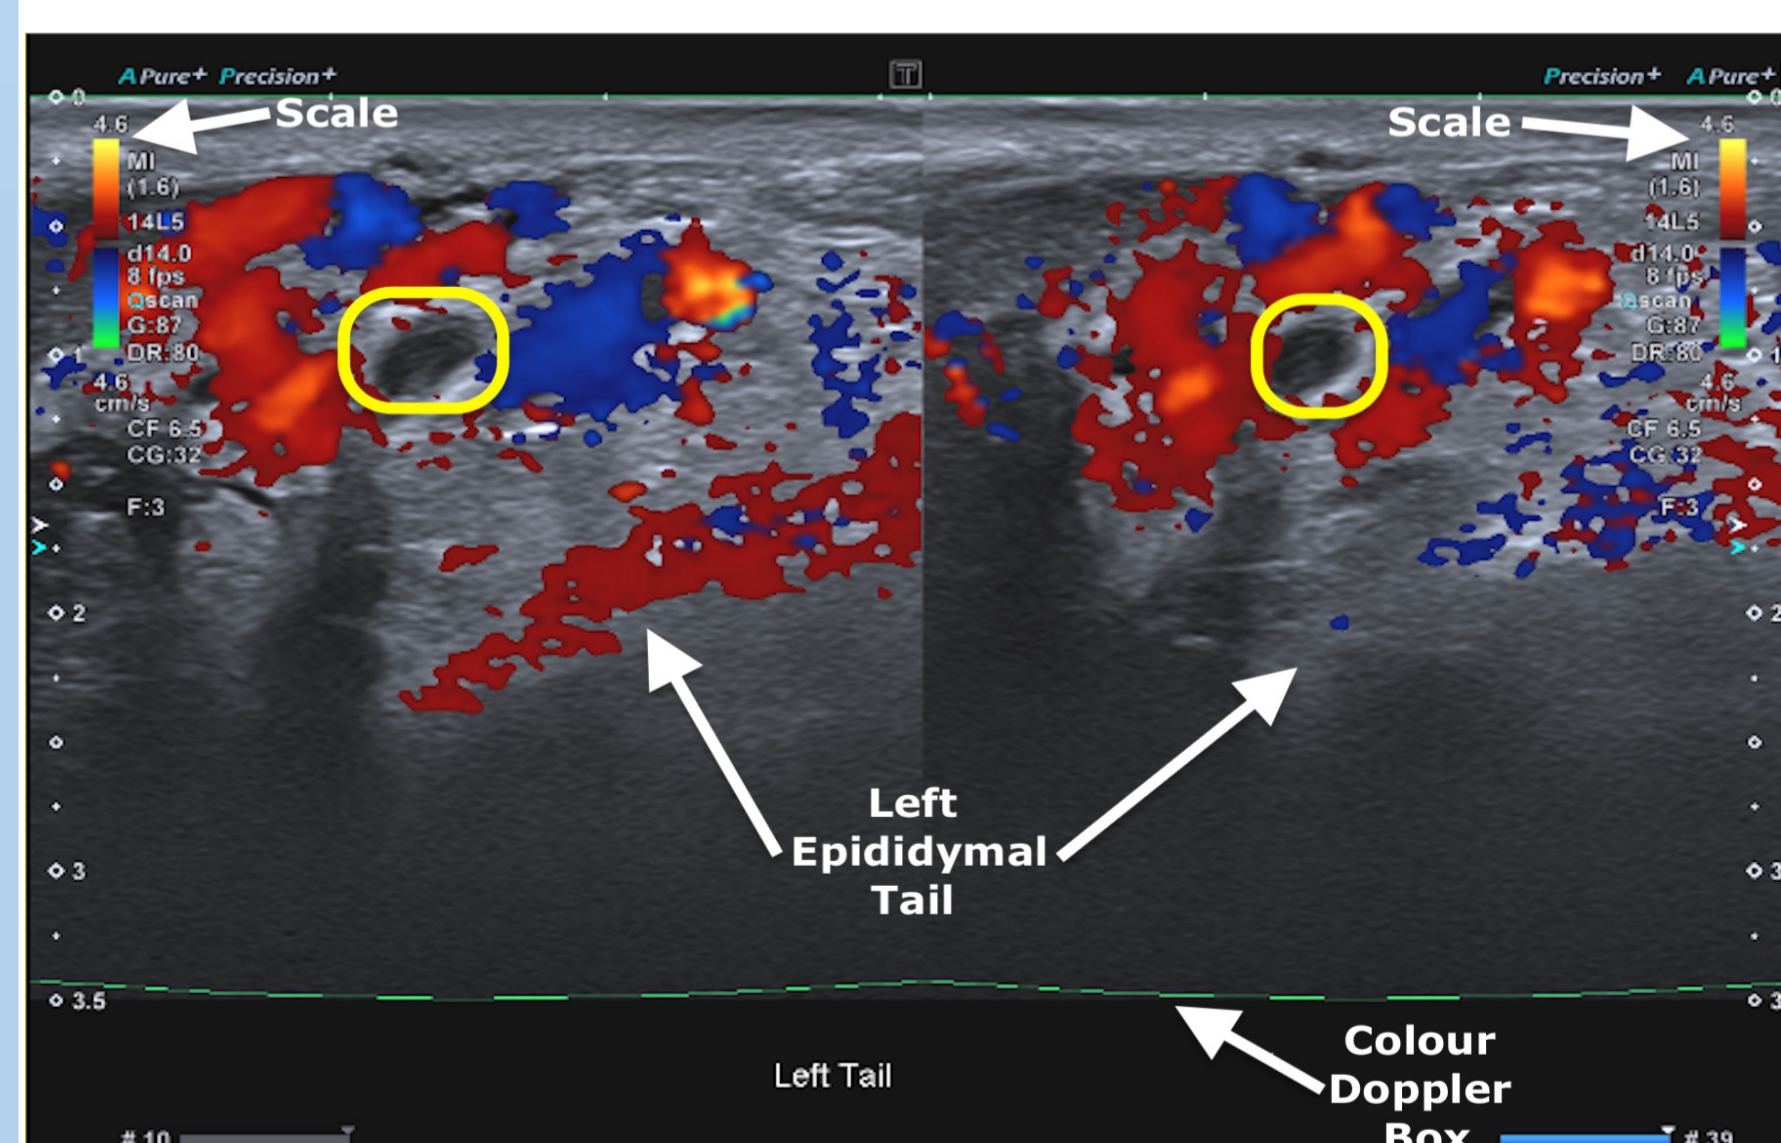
Colour doppler of the left epididymal tail, demonstrating blood flow within the varicocele, combined with a small avascular segment imaged during Valsalva (Hospital X, 2023).
